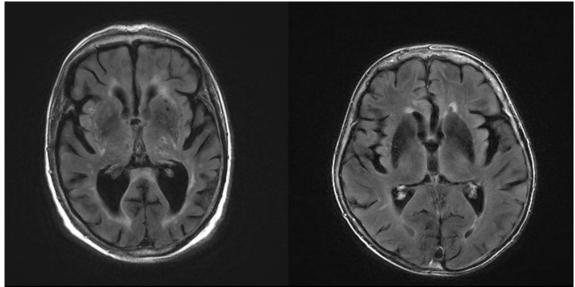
Left: Normal iron deposition in a patient with global cerebral atrophy (72 year and cogonitive impairment) on 3T-FLAIR MRI. The patient on the right also presented with mental decline but did not present atrophic changes (69 year old patient – 3T FLAIR MRI). However, the signal in the putamen is substantially reduced which is suspicious for iron deposition and therefore the presence of a neurodegenerative disesase
